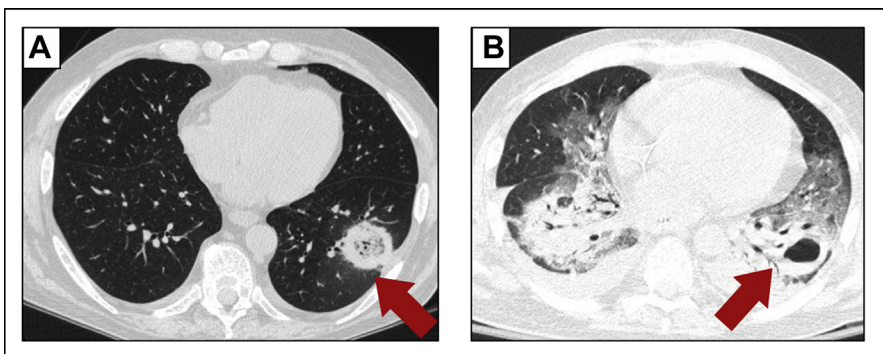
(A) Chest CT scan demonstrates a masslike lesion in the left lower lobe, with a focal area of ground glass attenuation surrounded by a ring of consolidation (reverse halo sign [arrow]). (B) Repeat chest CT scan shows interval worsening of diffuse ground glass opacities bilaterally as well as cavitation (arrow) of previously noted masslike consolidation in the left lower lobe despite treatment with L-AmB in a patient with progression of acute leukemia.
